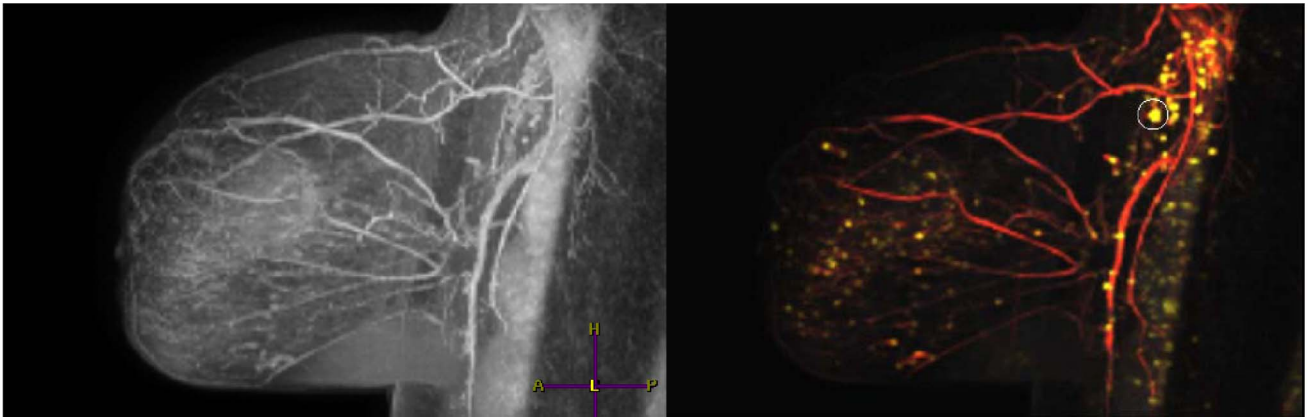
Axillary lymph nodes in a breast MRI, verified by clinicians. Left: standard MIP, lymph nodes are hardly visible. Right: Hessian-based shape-encoding rendering.
